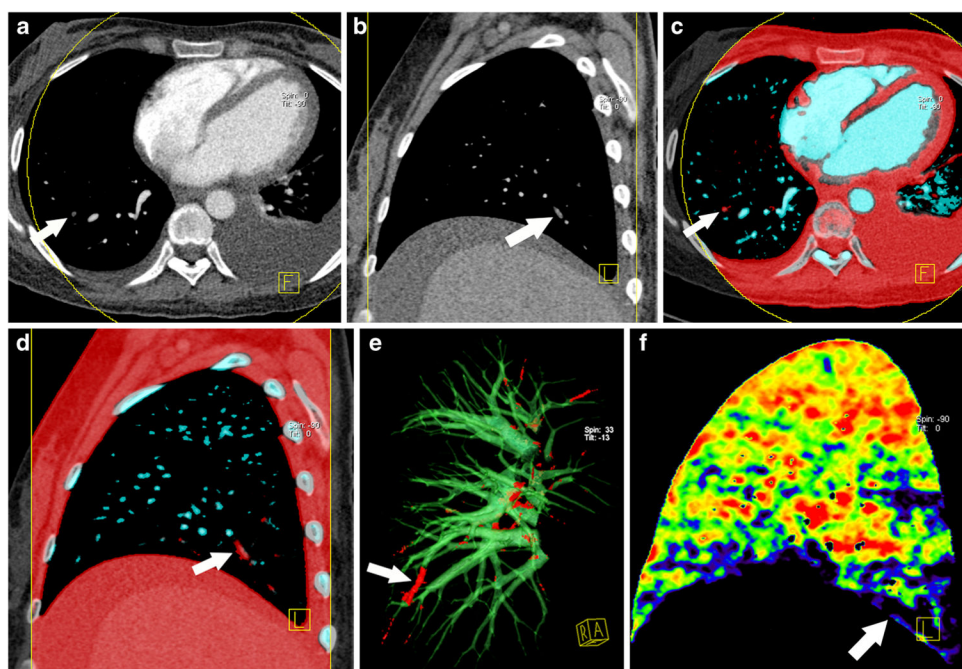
Dual-energy CT with vascular rendering in the detection of pulmonary embolus in a 14-year-old boy with podocytopathy. a–b Conventional CT images and (c–f) parametricized CT images from the same scan. Right lower pulmonary arteries are coded red (*arrows in c–e*) and the other pulmonary arteries are coded blue, which correspond to *arrows in a–b* in conventional CT pulmonary angiography. A perfusion defect is demonstrated with vascular rendering (*arrow in f*) in corresponding lung segment
